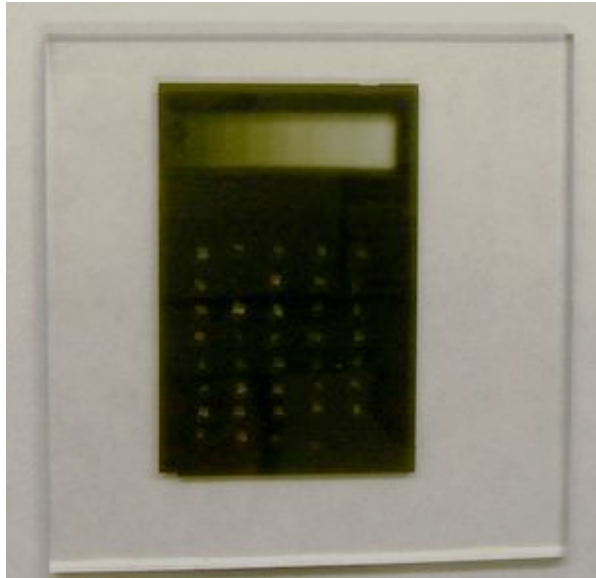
Radiographic plate after x-ray exposure and developing ready for TMR analysis.
